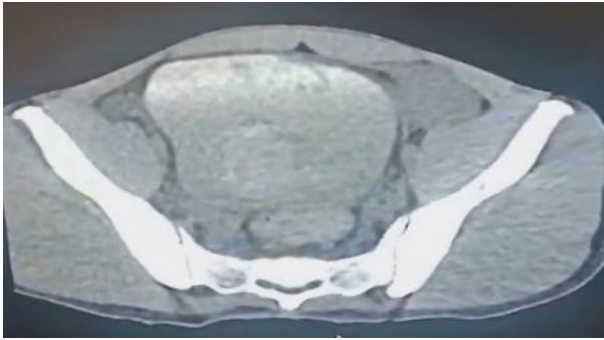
CT image at the level of bladder and rectum at the level of injury with bladder filled with blood clots.
